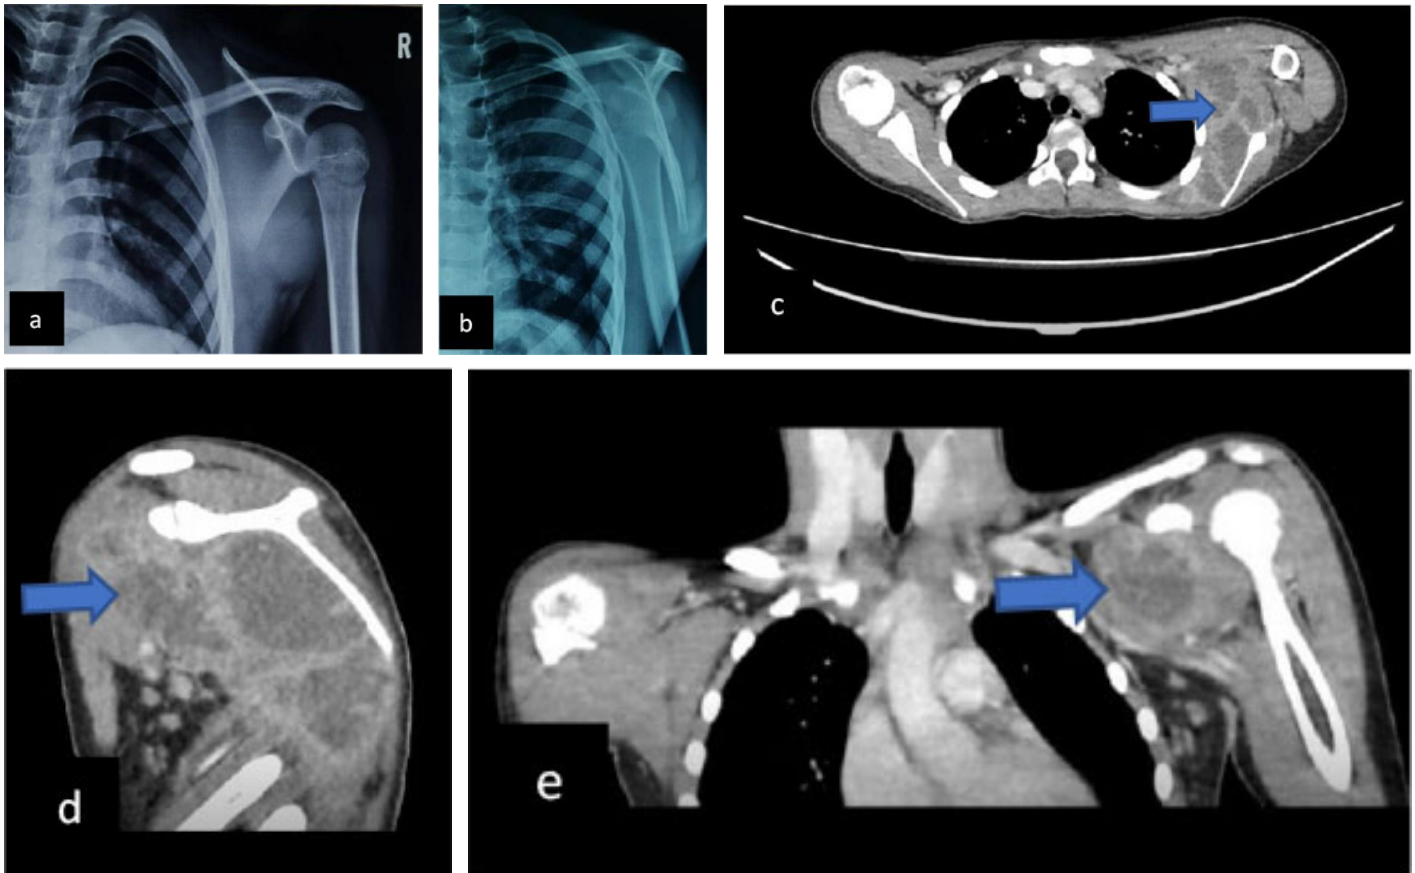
Radiograph of Shoulder.
